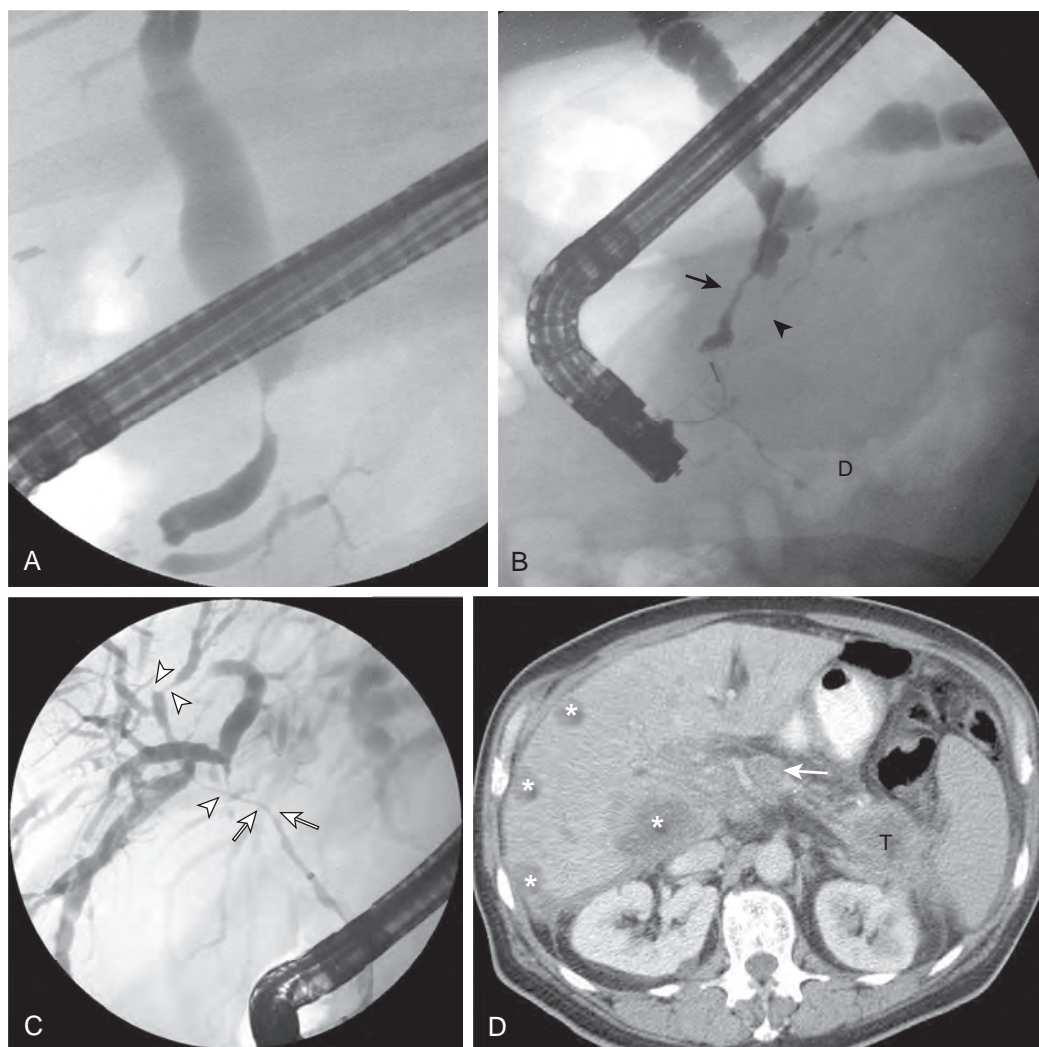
Biliary tract strictures from pancreatic carcinoma. A. The pancreatic cancer causes a rapid transition to a tight stricture in the intrapancreatic portion of the bile duct with marked upstream dilation. B. In this case, the pancreatic cancer has a longer bile duct stricture that is irregular in appearance (arrow). There is also a long diffuse narrowing of the pancreatic cancer in the adjacent main pancreatic duct (arrowhead). There is dilation of the upstream main pancreatic duct. There is also nodular effacement of the gas-filled duodenum from the pancreatic cancer. C. In a different patient, the proximal extrahepatic biliary tree (arrows) and intrahepatic bile ducts (arrowheads) are narrowed by metastatic disease to hilar lymph nodes and hepatic metastatic disease, respectively. D. The corresponding CT section demonstrates the pancreatic tail primary (T), metastatic hilar lymph nodes (arrow), and hepatic metastases (asterisks).
